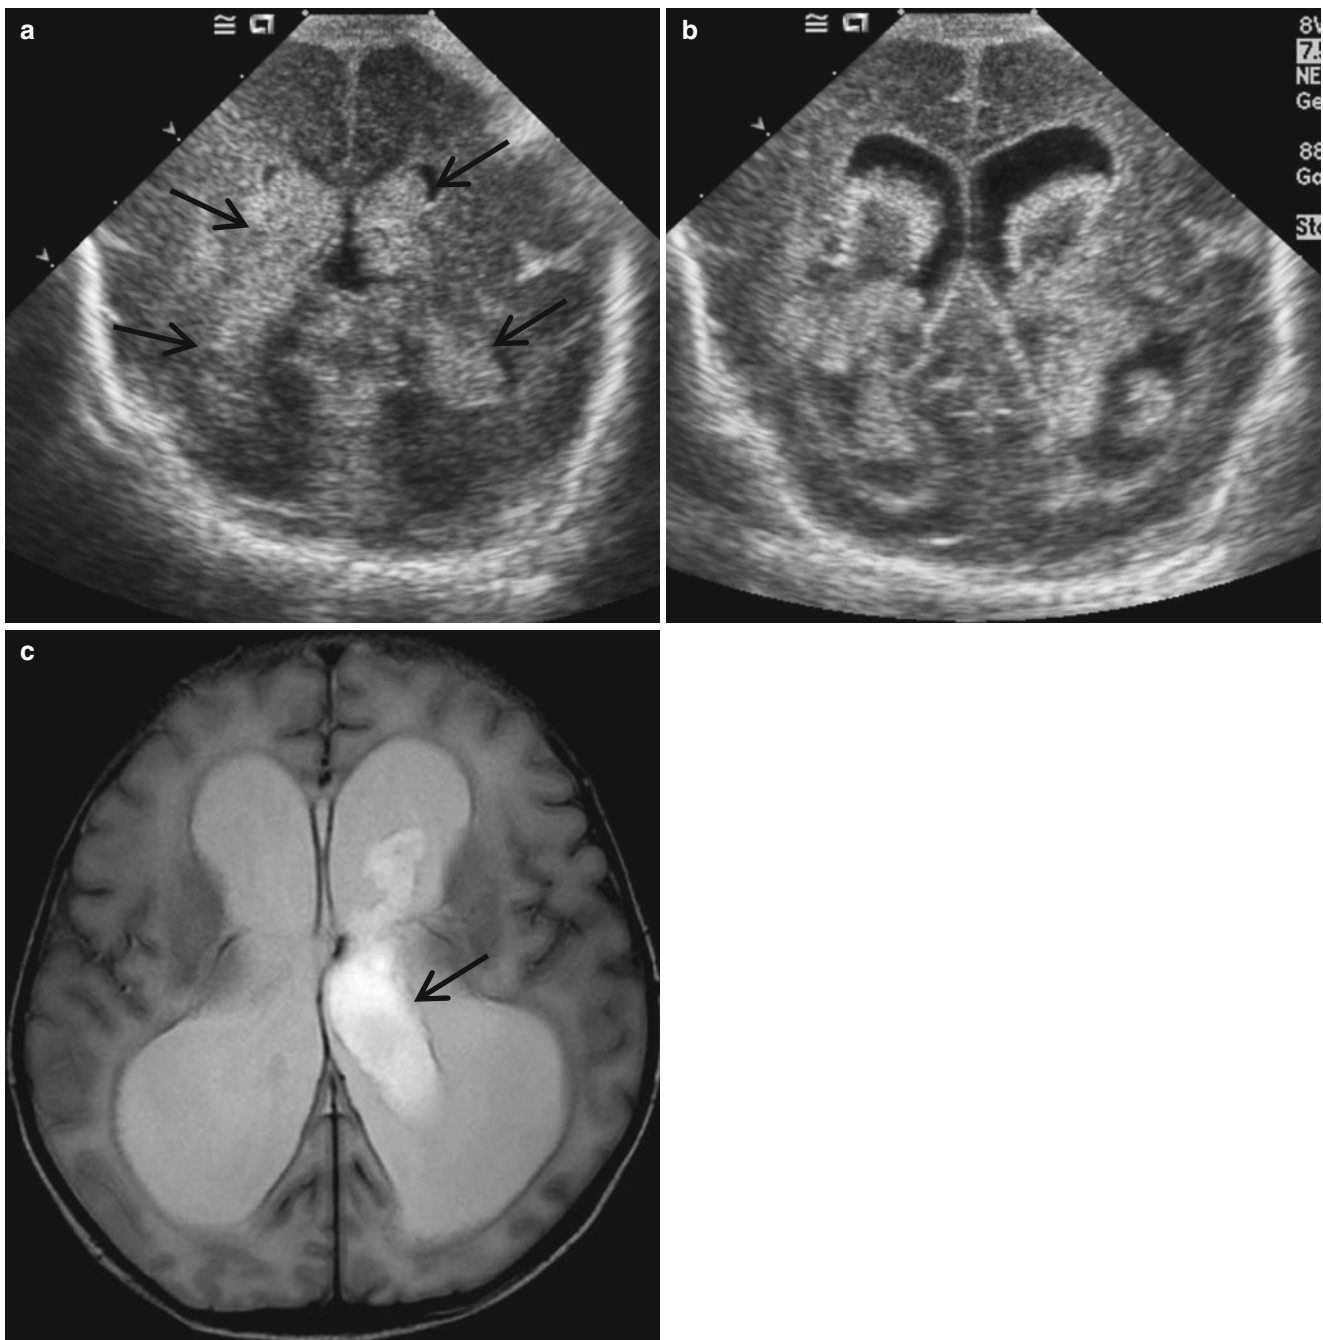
Grade 3 IVH. (a) Coronal sonogram shows bilateral large echogenic hemorrhage casting the ventricles. The ventricles are slightly distended. (b) Follow-up US obtained 1 week later reveals further enlarged ventricles and central hypoechoic area within the hematoma
